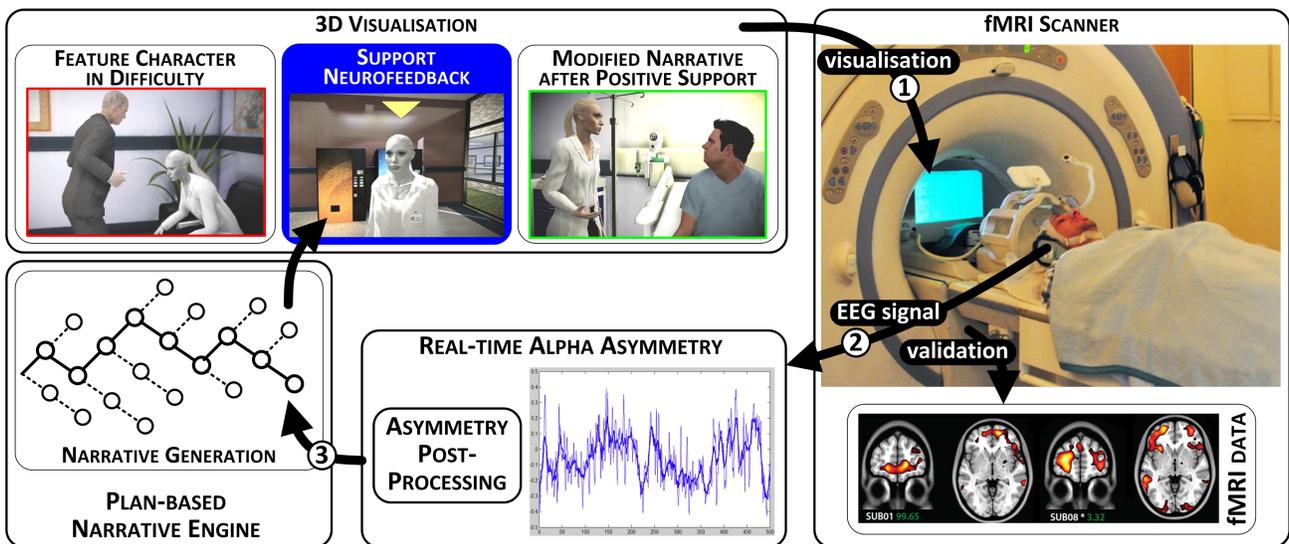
System Overview and Experimental Setting: (1) the user watches the narrative generated in real-time from inside an MRI scanner; (2) BCI input is interpreted in terms of empathy towards the feature character; (3) successful neurofeedback influences the narrative, improving the character’s situation.
